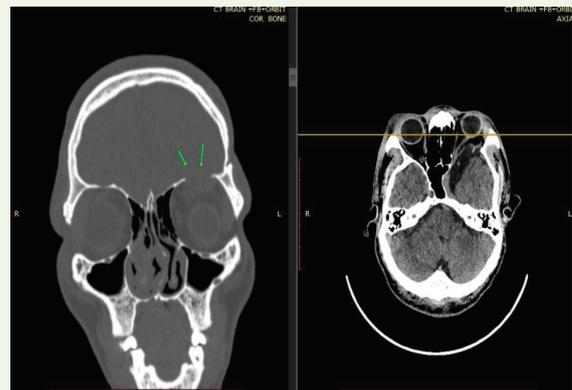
CT brain (CORONAL AND AXIAL) OF 39-YEAR-OLD GENTLEMAN WITH KNOWN NF-1 demonstrates hypoplasia of the left sphenoid wing (arrow) with loss of the normal bony separation between the middle cranial fossa and the orbit, allowing herniation of intracranial contents into the left orbit.
